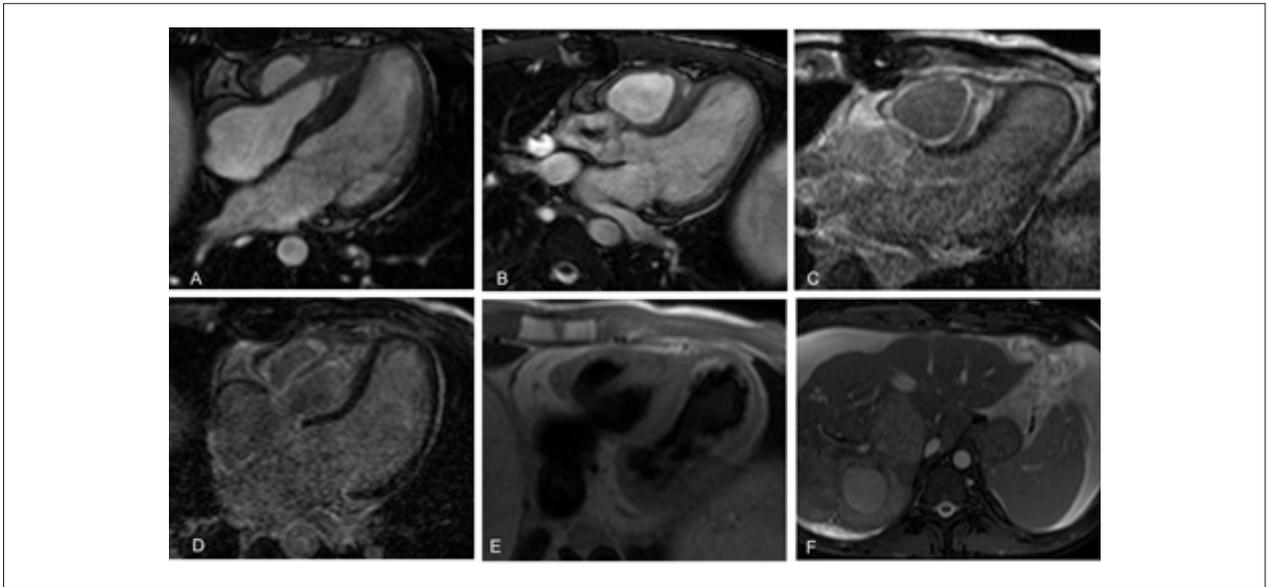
Cardiac magnetic resonance imaging evaluation. A and B) cine resonance magnetic imaging in 4-chamber and 3-chamber, respectively; there is an increase in the thickness of the free wall of the right ventricle and papillary muscle and a retracted tricuspid valve. The right atrium and the right ventricle appear as a single chamber. The interventricular septum is displaced to the left ventricle, suggesting an increased volume of the right ventricle. C and D) show the presence of late gadolinium enhancement (LGE) in the subendocardial region of the free wall, papillary muscle and interventricular septum. There was no LGE in the left ventricle. E) dark blood sequence with increased thickness of the right ventricular myocardium and absence of edema. F) images of the thoracoabdominal transition showing hepatomegaly, multiple hepatic nodules and ascites, characteristic of neuroendocrine tumors.
